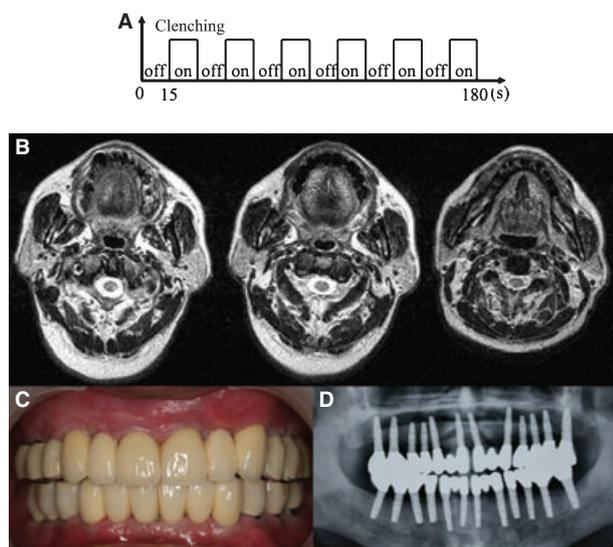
Task paradigm and images of one patient. (A) Task paradigm; (B) magnetic resonance images of one patient showing few artifacts around the implants; (C) intra-oral frontal view of the patient; (D) panoramic X-ray showing crowns and bridges supported by 24 implants.
